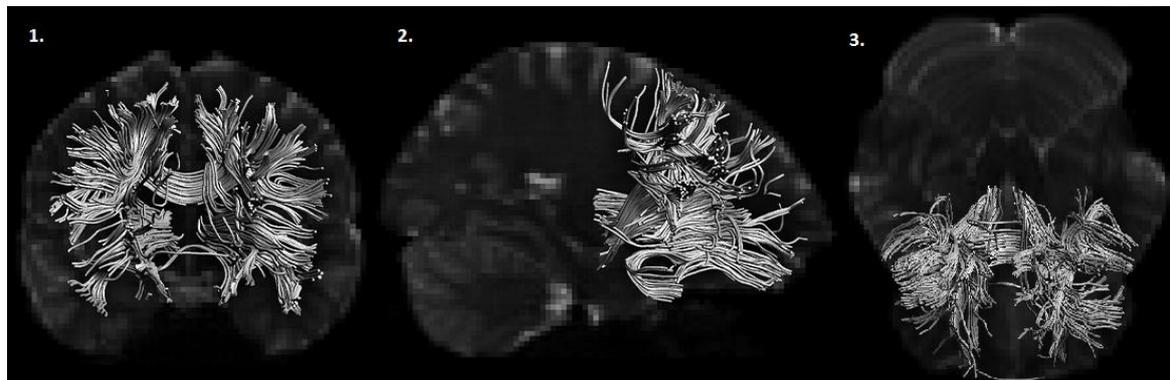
Massiveness of the prefrontal connectivity, obtained by diffusion tensor imaging in MRI. Image 1 shows white matter fibers in coronal slice, Image 2 in sagittal slice, Image 3 in axial slice.
